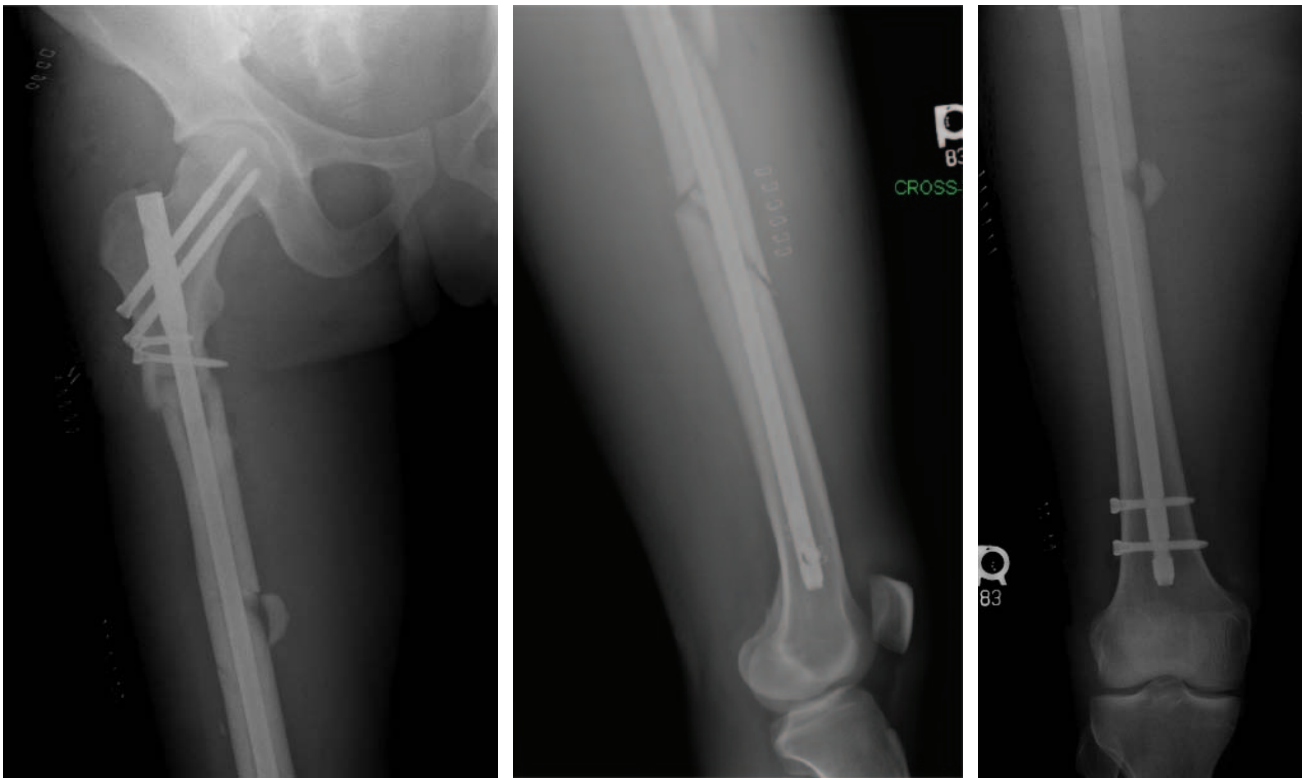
Intra-operative X-rays are performed prior to waking the patient and contaminating the surgical instrumentation. These are essential to ensure extra-articular placement of implants as well as gross alignment. Length and rotation are also evaluated clinically prior to waking the patient.
